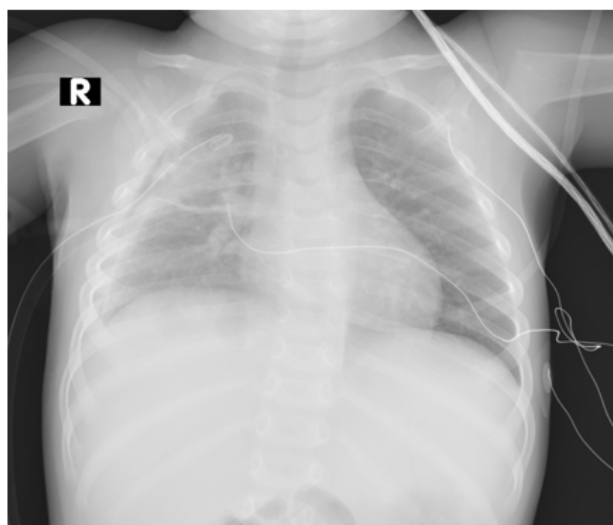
Xray post chest tube insertion.
